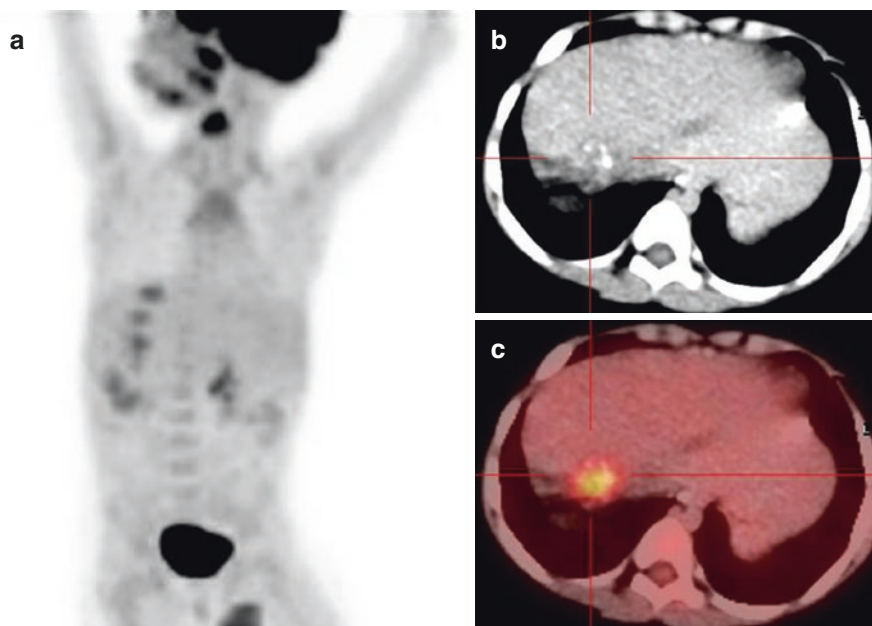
Case of hepatoblastoma treated with chemotherapy followed by surgery and maintenance chemotherapy. On follow-up presented with elevated AFP level. Contrast CT scan did not reveal significant abnormality at the postoperative site or distant regions, a FDG PET/CT done revealed increased FDG uptake at the postoperative margins as seen on the MIP images (a) and on the fused transaxial PET/CT image (c) though no abnormality was seen on the correlative CT image (b). USG-guided biopsy confirmed recurrence on the diaphragmatic surface of the peritoneum overlying the liver
